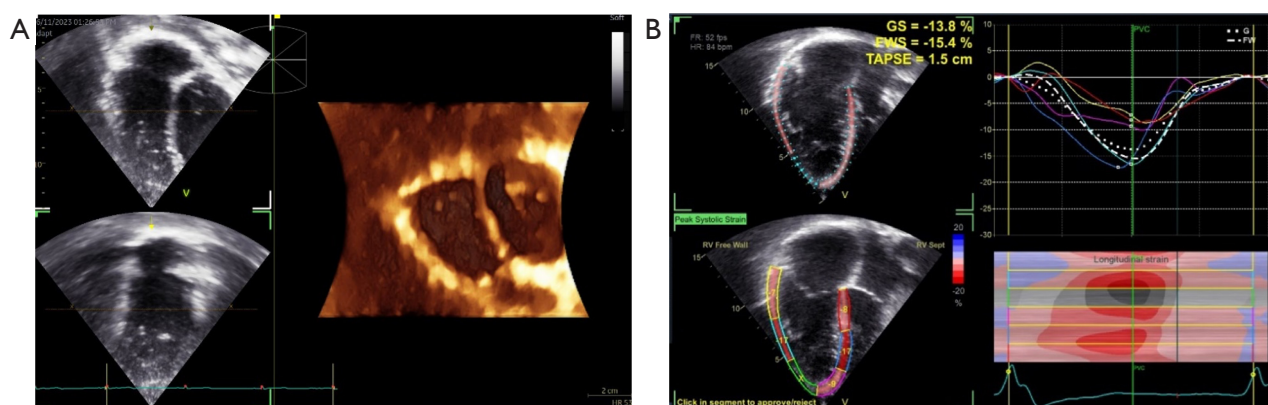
Advanced echocardiography techniques in TOF. (A) 3-dimensional echocardiography volume rendering-image of dilated right ventricle and normal sized left ventricle (colored image) of a 10-year-old girl with repaired tetralogy of Fallot. (B) Decreased global longitudinal strain in an 18-year-old boy with repaired tetralogy of Fallot. GS, global longitudinal strain; FWS, free wall strain; TAPSE, tricuspid annular plane systolic excursion; TOF, tetralogy of Fallot.
